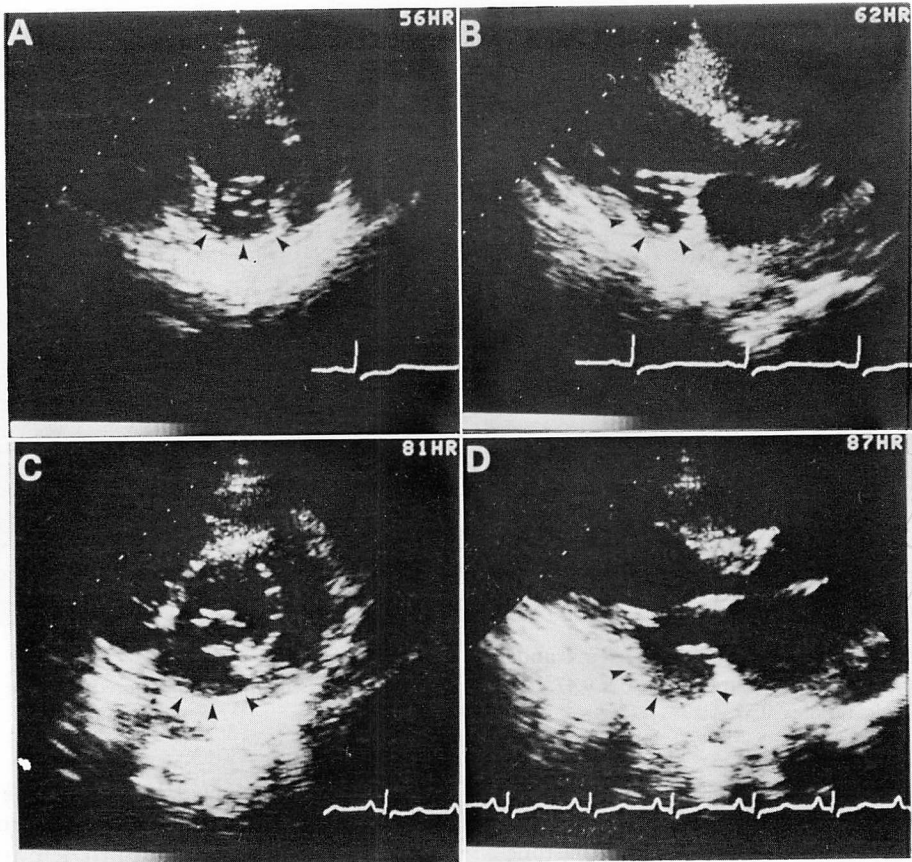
Two-dimensional echocardiograms of the siblings.
